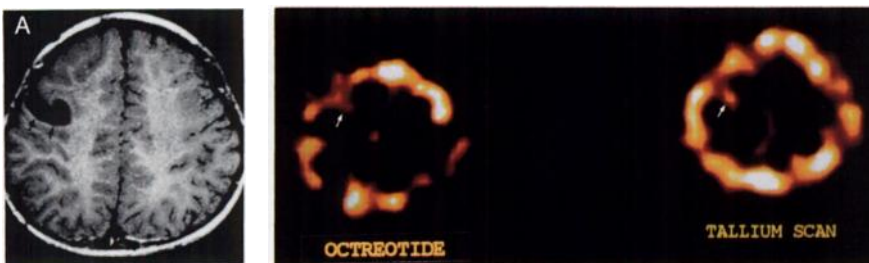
A 4-yr-old child with a low-grade astrocytoma at right frontal lobe. (A) Gd-enhanced MRI shows a nonenhancing low signal intensity mass (arrows). (B) SPECT images show minimal uptake of radiotracers at the lateral aspect of the tumor (arrows).
